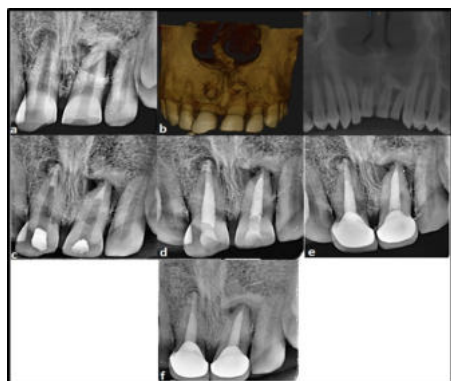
a) Preoperative radiograph depicting periradicular radiolucent lesion surrounding the apices of 11 and 12;b) Working
